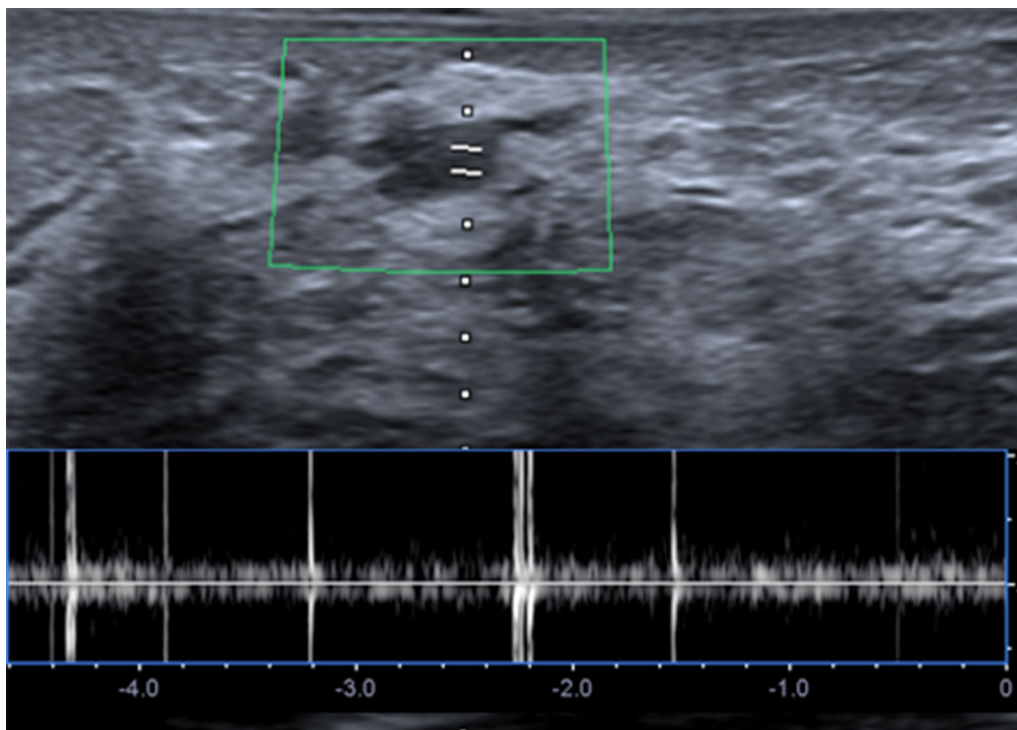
Power Doppler of the curvilinear hyper echogenic area reveals non-rhythmic, non-pulsatile signal within
